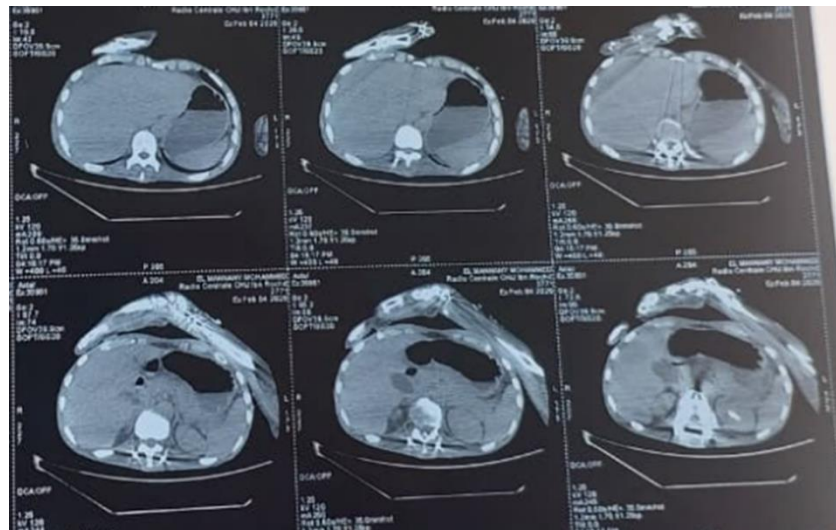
Abdominopelvic CT scan demonstrating a pneumoperitoneum located in the supra-mesocolic compartments
